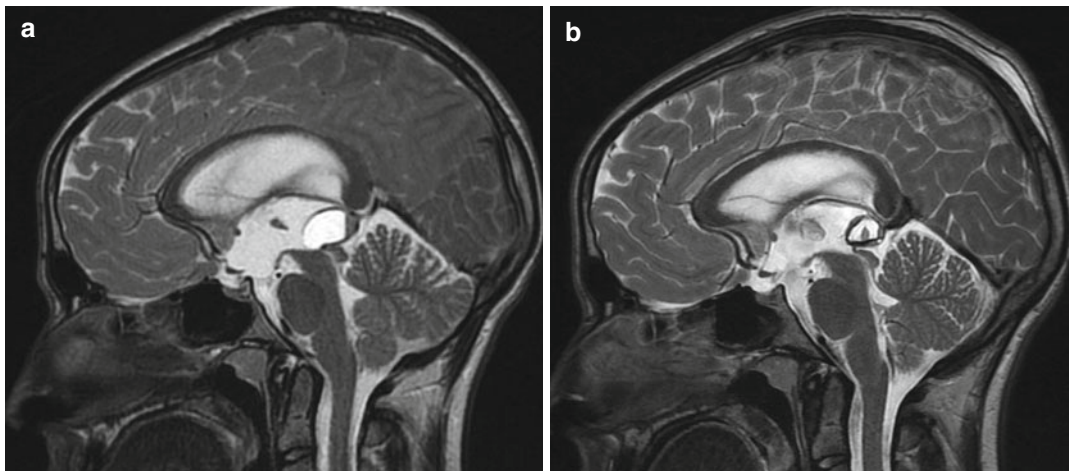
Sagittal T2-weighted MRI before (a) and after (b) endoscopic fenestration of a cystic tumor at the rostral mesencephalon. This adolescent male required no further therapy for a biopsy-proven low-grade glial tumor
